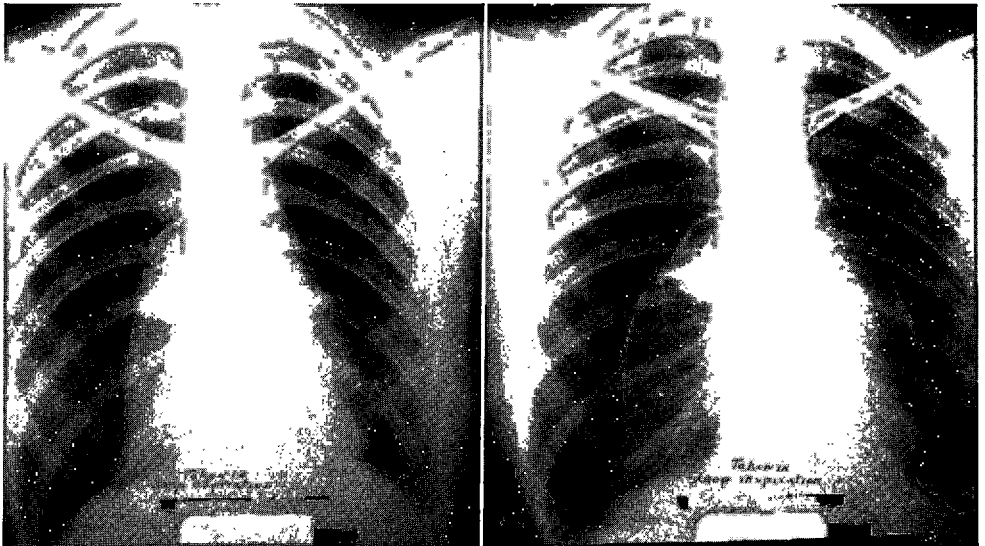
Two roentgenograms of the chest of a young, white man taken during deep expiration on left and on deep inspiration on right. This patient was being treated for bilateral pulmonary tuberculosis by bilateral pneumothorax. Note marked degree of collapse of both lungs by therapy. Since the requirements for oxygen at rest were quite low and since this was a relatively young individual, this marked degree of reduction in lung capacity was tolerated.
